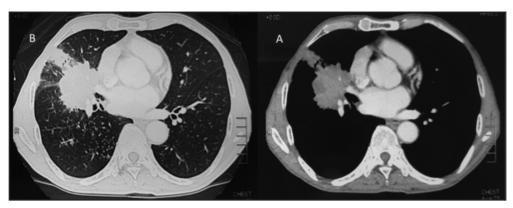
A) A chest CT in lung window axial view showed speculated, mass-like lesion near at right lower lobe. There was neither grass-ground opacities nor lung parenchymal consolidation; B) The CT in mediastinal window axial view showed similar findings as in figure 2A.
